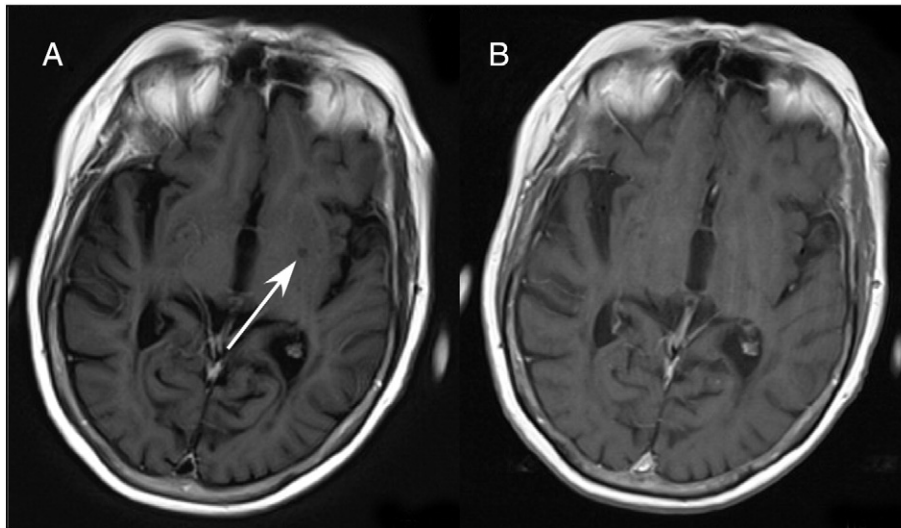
Sequences: T1W FLAIR BLADE with contrast medium (A), T1W SE with contrast medium (B). T1W FLAIR BLADE achieves CSF nulling, thus lesions with low signal can be better visualized. The arrow shows the ischemic stroke which is not depicted in the conventional T1 sequence.
